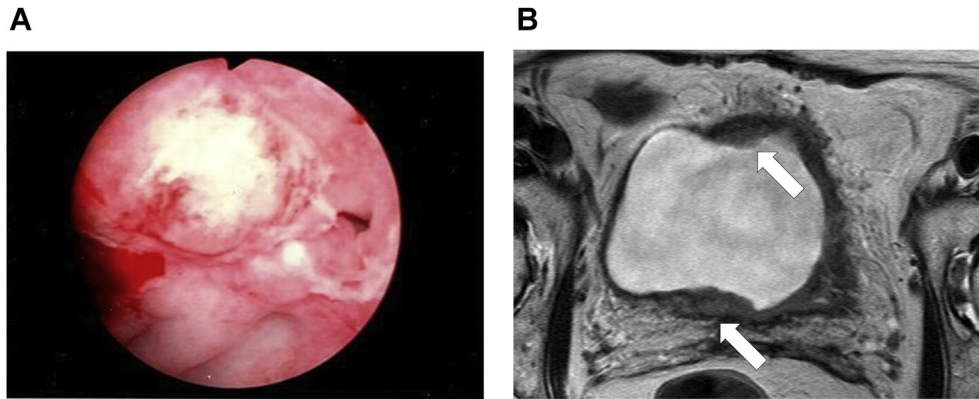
Cystoscopy and MRI at presentation. Cystoscopy showed reddish edematous mucosa on the posterior wall of the bladder (A). MRI showed mass lesions on the anterior and posterior walls (B, arrows). T2-weighted image.
